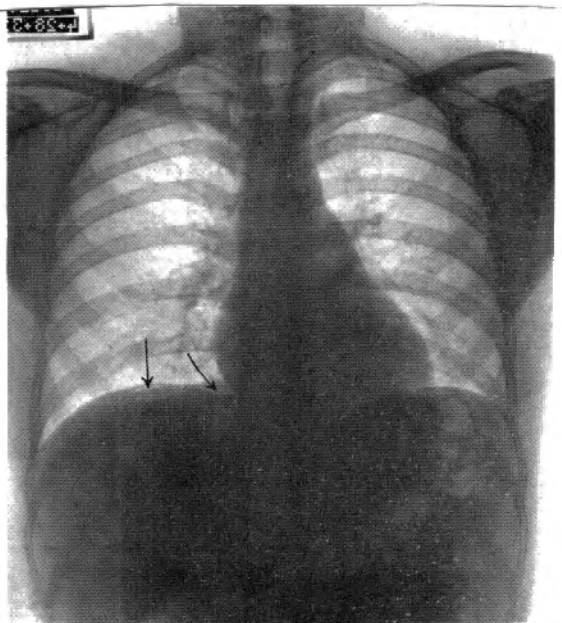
Case 4. Roentgenogram taken 2½ days after perforation. The thin zone of intraperitoneal air (indicated by arrows) was the only clinical evidence at this time of a perforated viscus.
